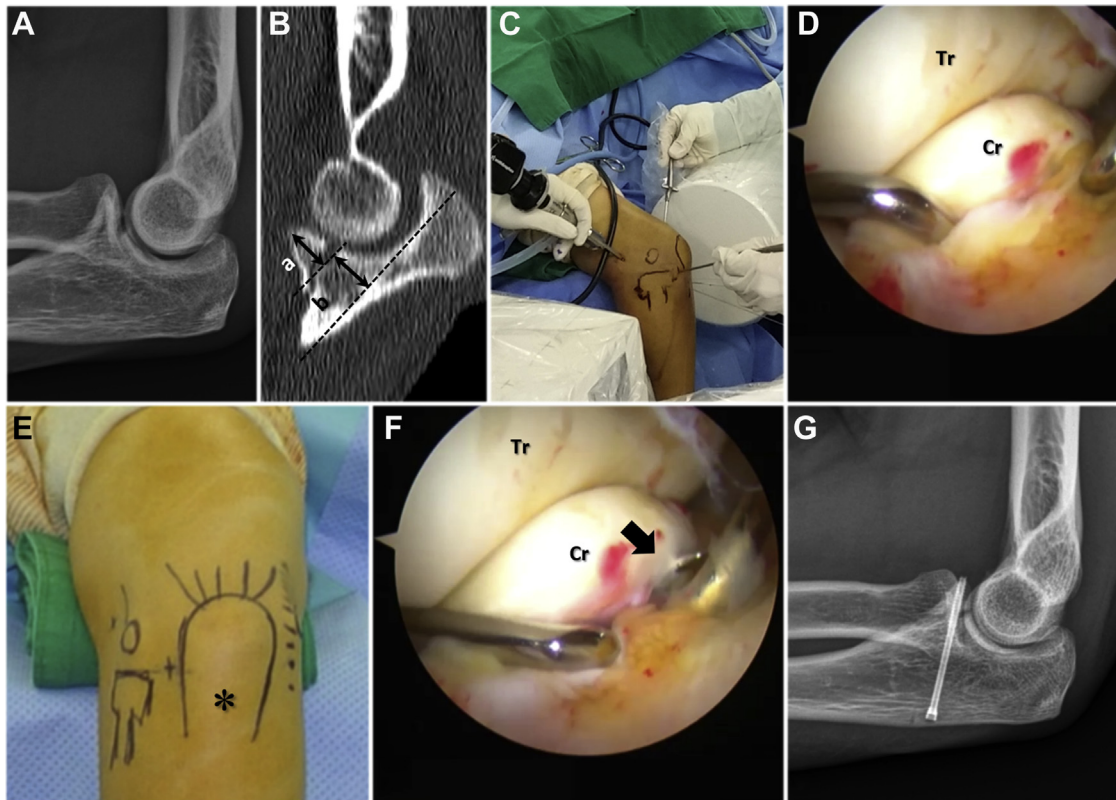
Arthroscopy-assisted reduction and fixation surgical technique for coronoid fracture. (A) Lateral view of the elbow radiograph shows a fracture of the coronoid process of the ulna. (B) On the sagittal view of the computed tomography, the percentage coronoid height ($a / (a + b) \times 100$) was measured to classify according to Regan-Morrey classification. The joint subluxation (eccentric position of the trochlea) is shown, suggesting residual instability of the elbow. (C, D) With the patient in a prone position, the proximal anterolateral portal is used as a viewing portal, whereas the proximal anteromedial and posterior transarticular portals are used as working portals. An arthroscopy-assisted reduction is performed using 2 probes while an assistant maintains the operative view by holding an arthroscope. (E, F) After the reduction, a Kirschner wire is inserted to fix the fracture fragment. The entry point is the midpoint along the posterior aspect of the olecranon on the same level of the radial head (*), inserted slightly proximal to the targeting tip of the coronoid process (➡). (G) Lateral view of a postoperative radiograph shows that a headless compression screw, changed along the Kirschner wire as a guide pin, is appropriately holding the fracture fragment. Tr, trochlea; Cr, Coronoid process.
